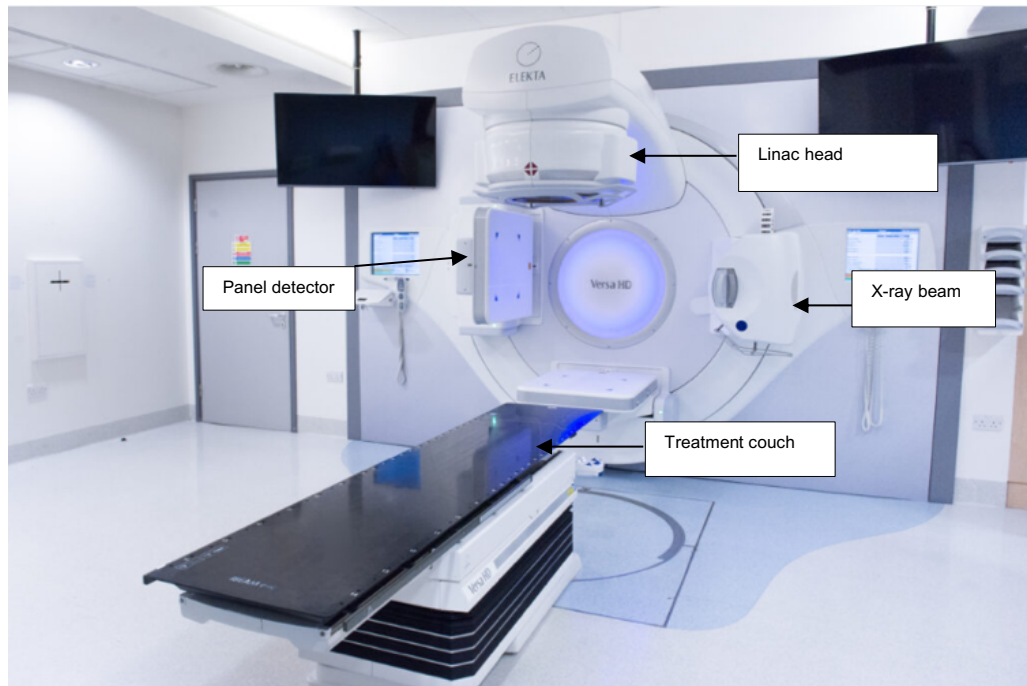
Elekta linear accelerator system, showing key components including the linac head, cone-beam CT (CBCT) unit, and treatment couch, which is used for external beam radiotherapy, replicated from [37].
